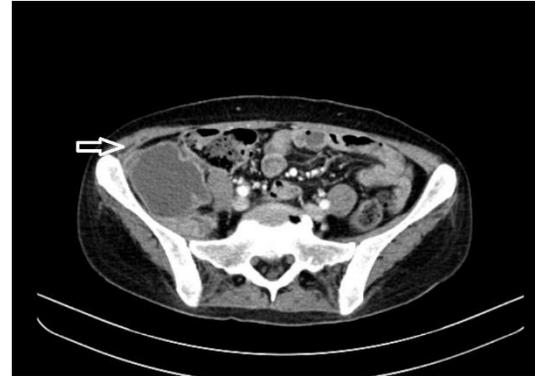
Retroperitoneal abscess on computed tomography.
